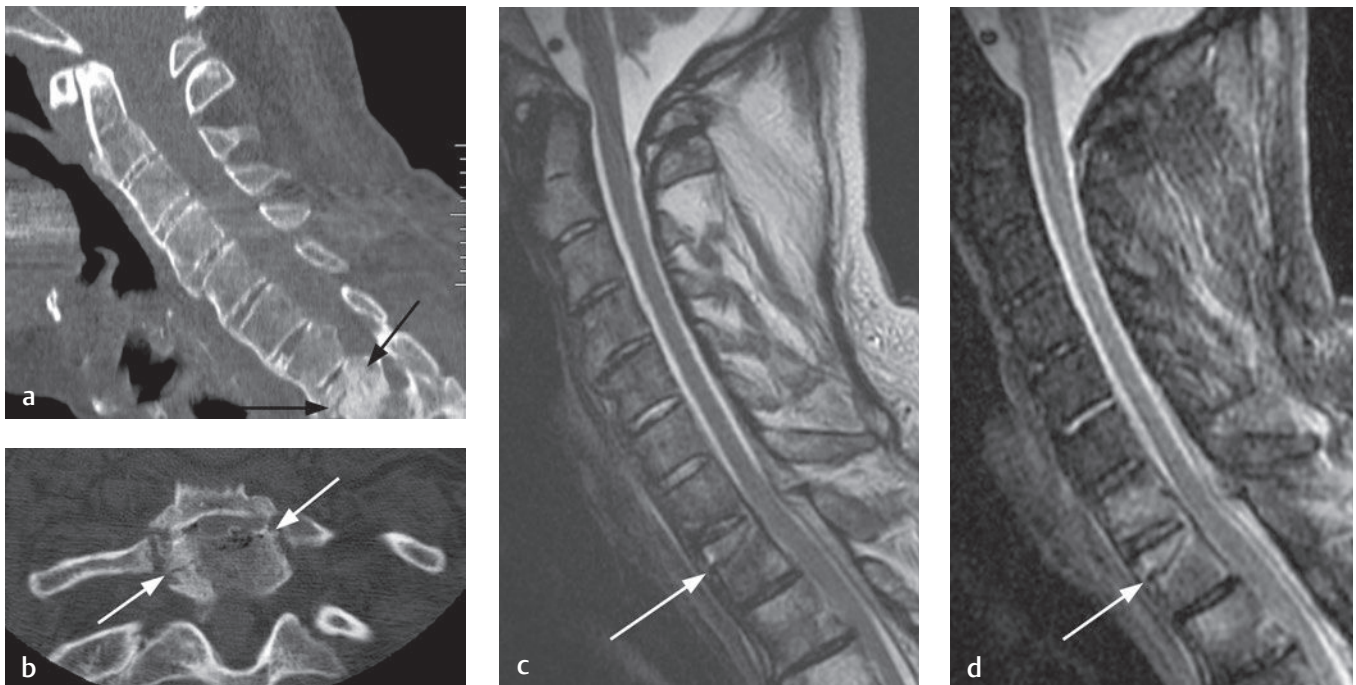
Ankylosing spondylitis. (a) Sagittal and (b) axial CT images of the cervical spine in a patient with ankylosing spondylitis show a nondisplaced fracture at the T1 level (arrows on each), which could easily be missed. (c) Sagittal T2-weighted and (d) STIR images show the same fracture (arrows on each). In (d), edema at the fracture site indicates a relatively acute injury. (From Khanna AJ, Kwon BK. Subaxial cervical spine injuries. In: Rao RD, Smuck M, eds. *Orthopaedic Knowledge Update: Spine 4*. 4th ed. Rosemont, IL: American Academy of Orthopaedic Surgeons, 2012:221–233. Reprinted by permission.)
